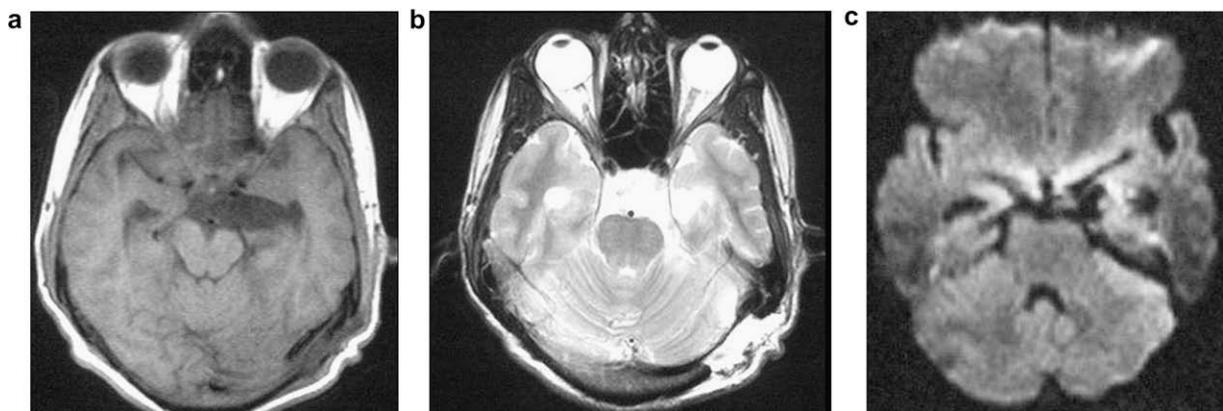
Postoperative (a) axial fluid-attenuated inversion recovery MRI scan, (b) axial T2-weighted MRI, and (c) diffusion-weighted MRI showing the excision of the tumor. Note the evidence of a retrosigmoid craniectomy.
